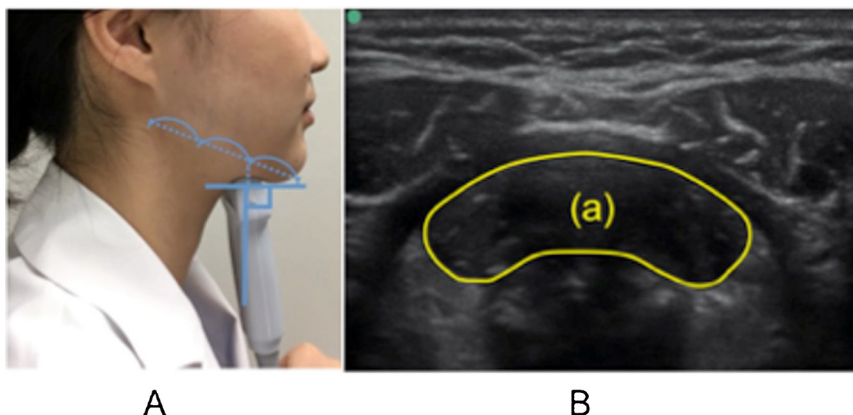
Ultrasonographic measurement of the geniohyoid muscle (GH). (A) Position of the probe. (B) Ultrasonographic image of the (a) GH.
